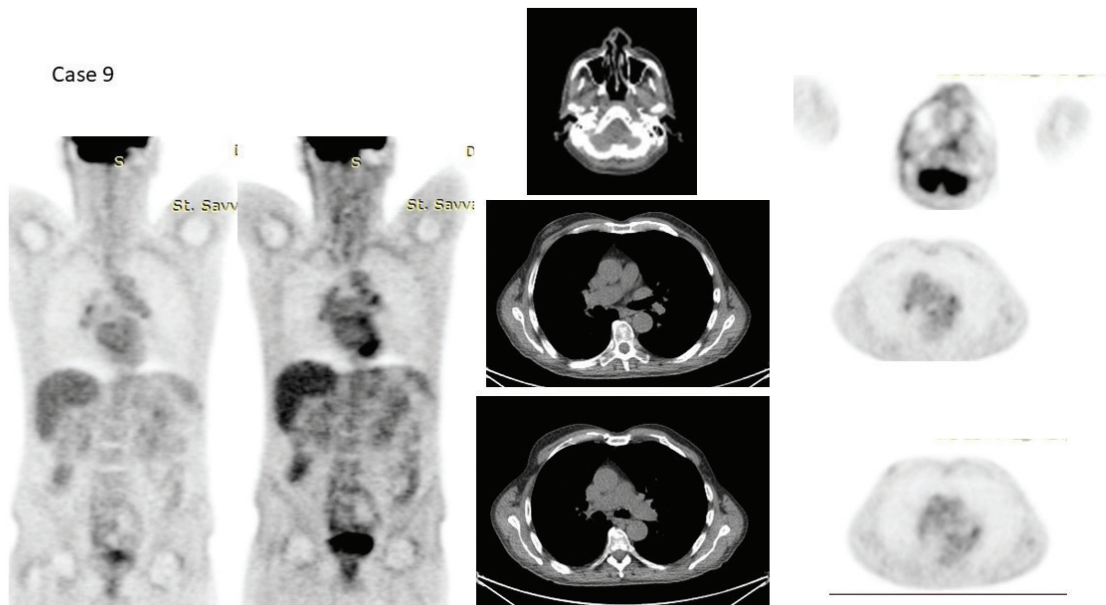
End treatment evaluation- Enlarged lymph node of right pulmonary hilum with high-grade uptake (SUVmax=4,3). Left pulmonary hilum lymph node with high-grade uptake (SUVmax=3,7). High-grade uptake at the posterior wall of the nasopharynx (SUV max=6,3).
